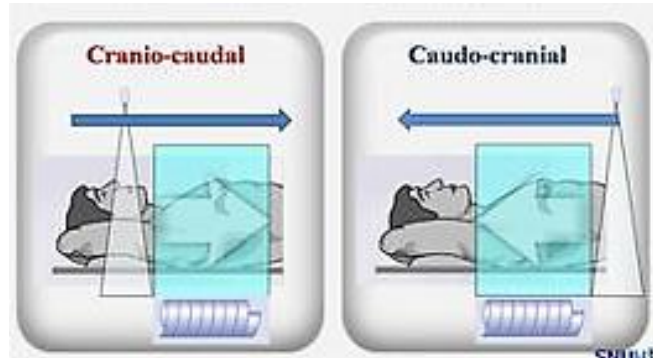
CT scanning directions
